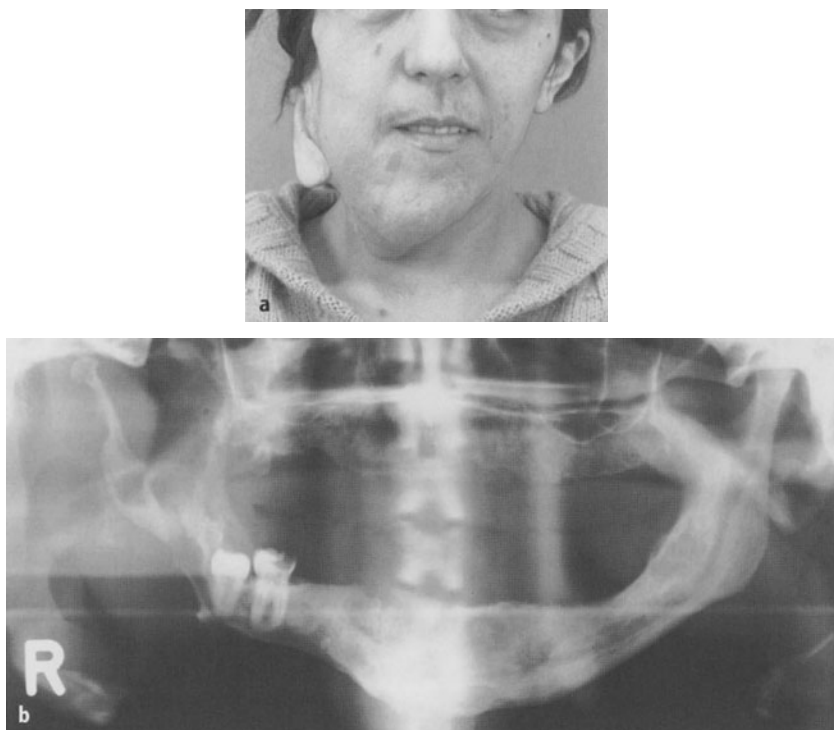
Neurofibromatosis producing an appearance similar to an unilateral H.H. a Elongation of right side of the face similar to unilateral H.H. b The panoramic radiograph discloses a pathology of the mandible which excludes automatically any possibility of a H.H.
